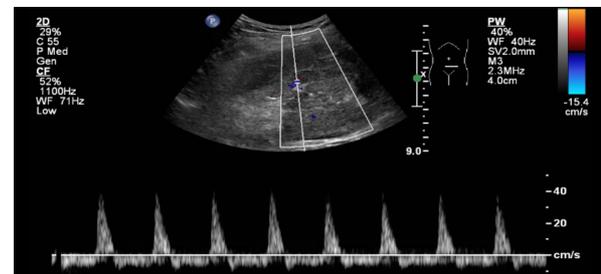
Doppler tracing demonstrating a pendular "to-and-fro" pattern with reversed diastolic blood flow.
